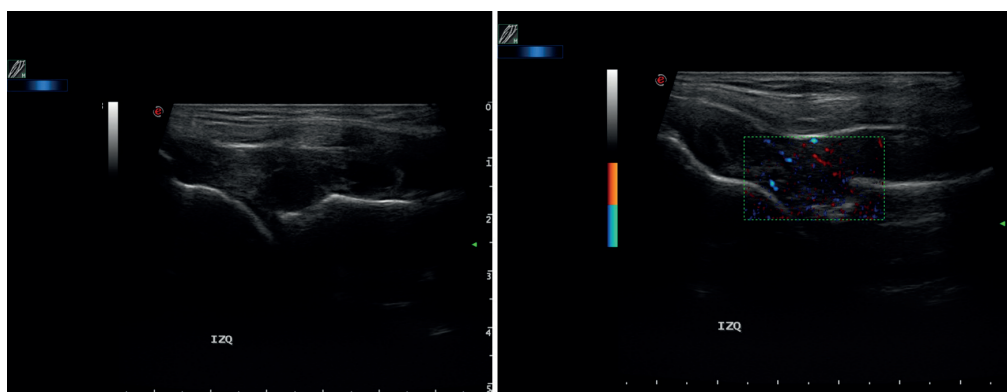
Marked thickening of the tibiotalar synovial membrane, with heterogeneous and hypoechoic appearance and diffuse increase in vascularization pattern with Doppler study. The synovial membrane widely distends the anterior recess of the joint, leading a mass effect on the extensor tendons.
